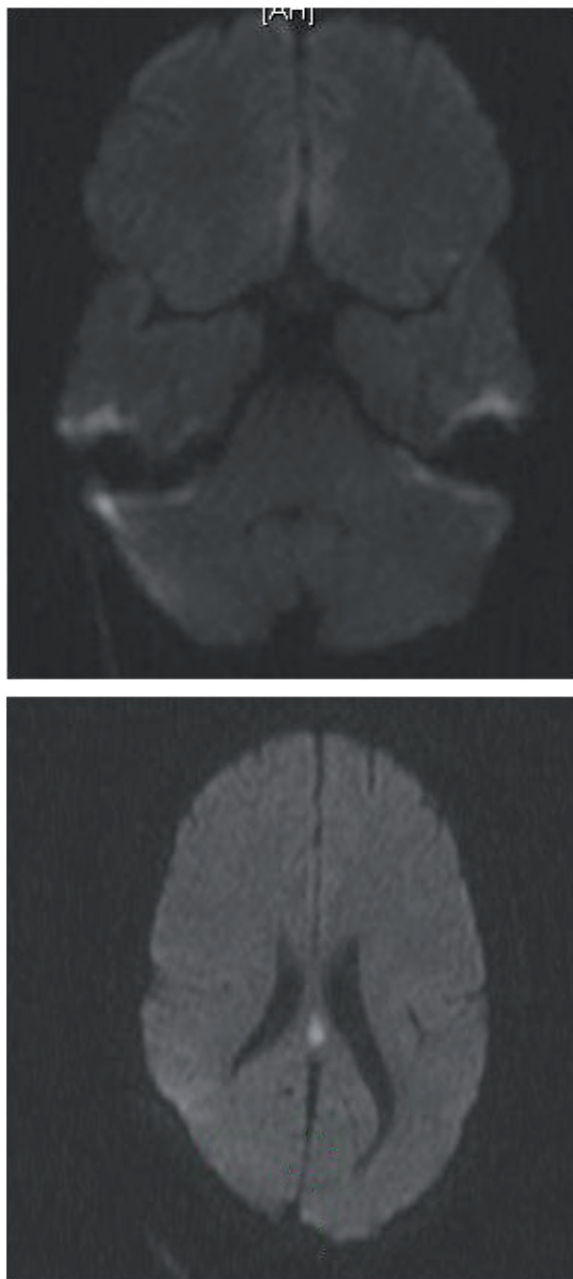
Diffusion-weighted MRI of the brain shows the presence of the lesion in the splenium; however, it does not show the lesion in the dorsal medulla seen on T2 and FLAIR images. This shows that the two lesions are distinct in their etiology.
